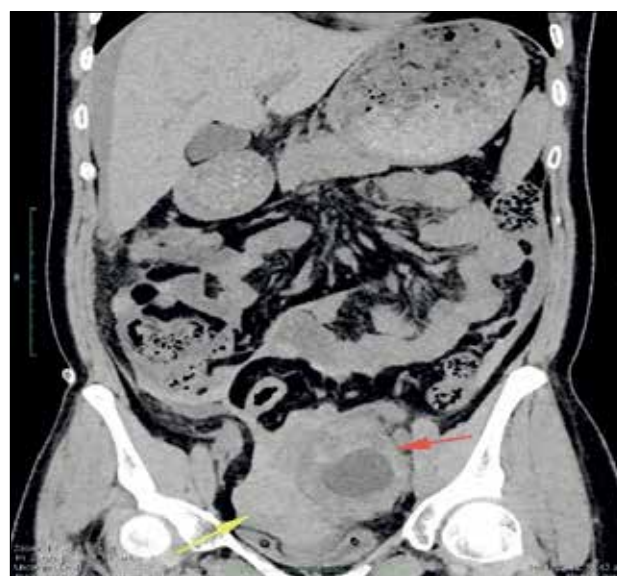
Non-contrast coronal computed tomography image showing haemoperitoneum (yellow arrow) and a thick-walled left adnexal cyst (red arrow).
